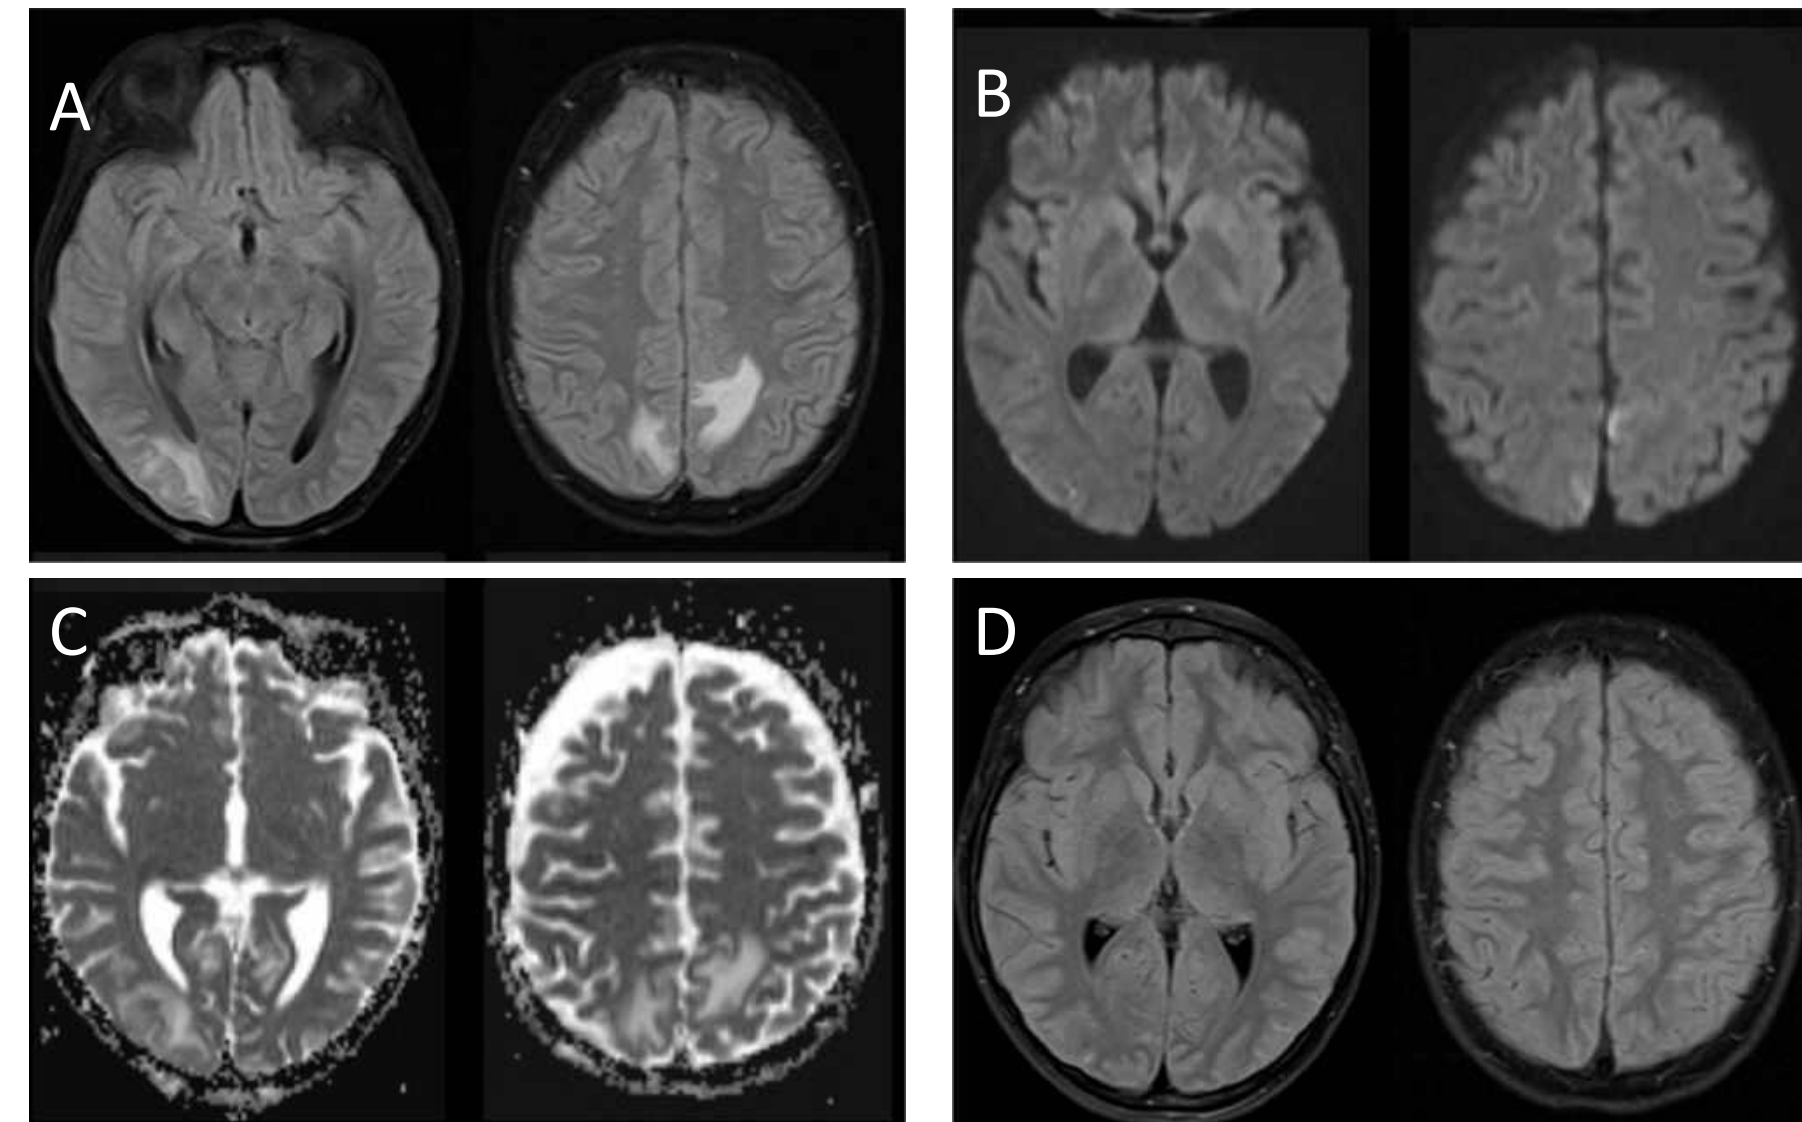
A, B, C- FLAIR-weighted MRI, DWI, ADC. Hyperintense lesions on FLAIR in right occipital subcortical and paramedian posterior parietal topography, without diffusion restriction. D- FLAIR-weighted control MRI showing full recovery.
